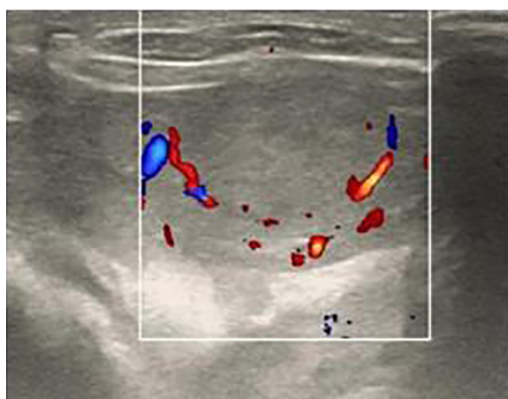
Preoperative CDFI showing a peripheral annular blood flow signal. CDFI, color Doppler flow imaging.
